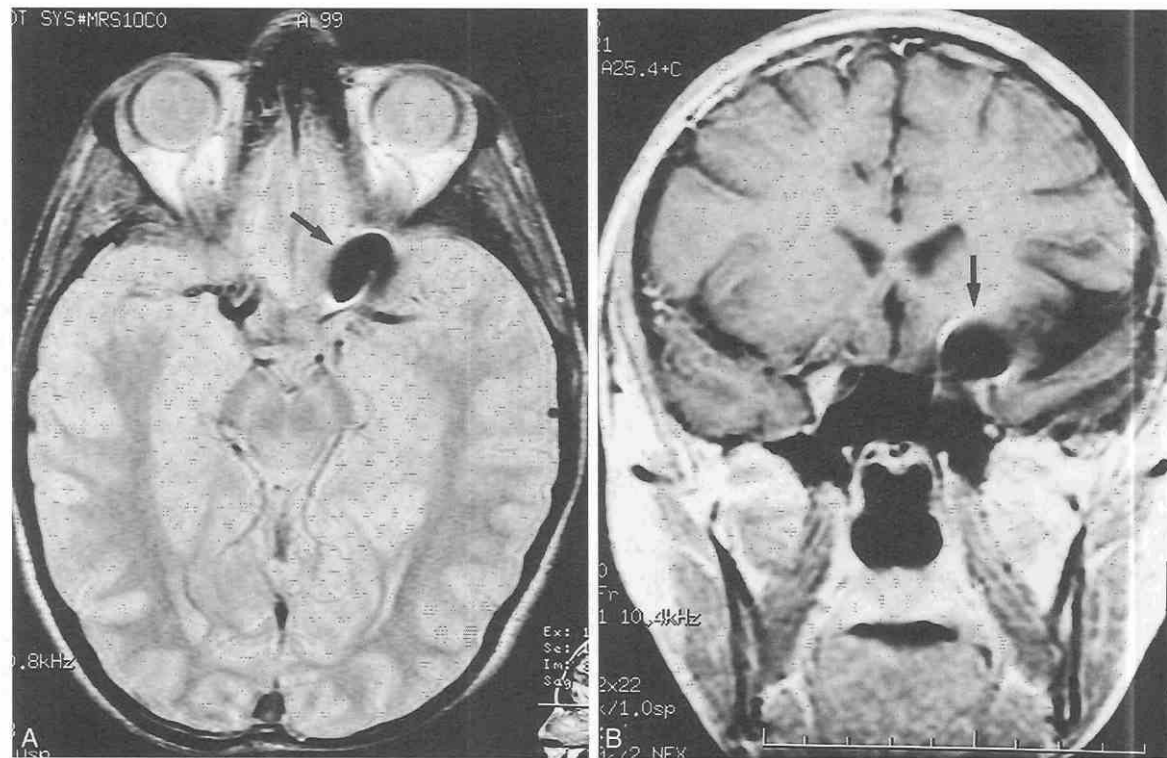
Ferromagnetic artifact produced by cerebral aneurysm clip on MRI. Short TE, long TR (A) and coronal post-contrast T1-weighted (B) images demonstrating an ophthalmic aneurysm clip (arrows).
